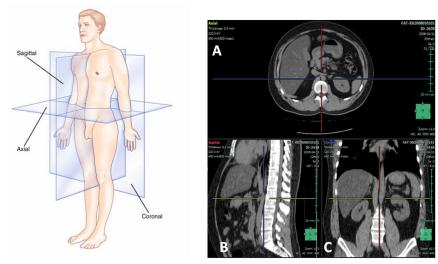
(left) Three orthogonal directions of the medical imaging of the human body; (right) A, B and C axial, sagittal and coronal views respectively of a CT study (Fuji Synapse).
